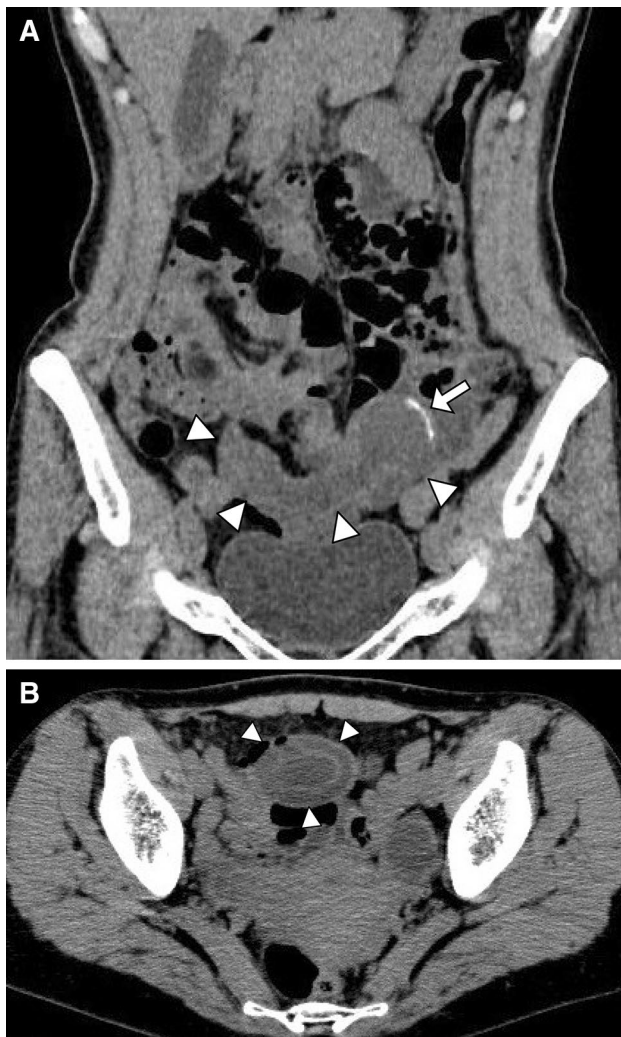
Abdominal CT scan (a and b) showed smooth cystic bulge with calcification at the left side of the lesion (*arrow*). It showed a concentric circles structure (b)
